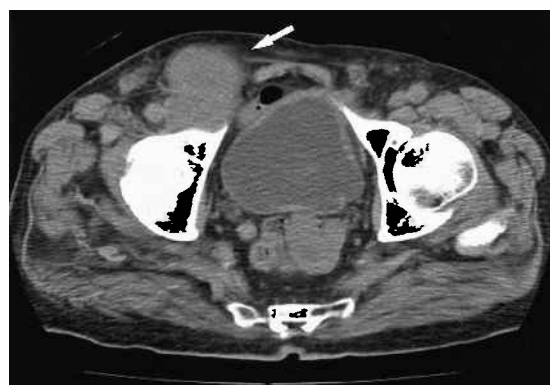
Non-contrast CT image, performed 15 months after the resection of the primary lesion, shows a recurrent tumour in the right inguinal region (arrow).
